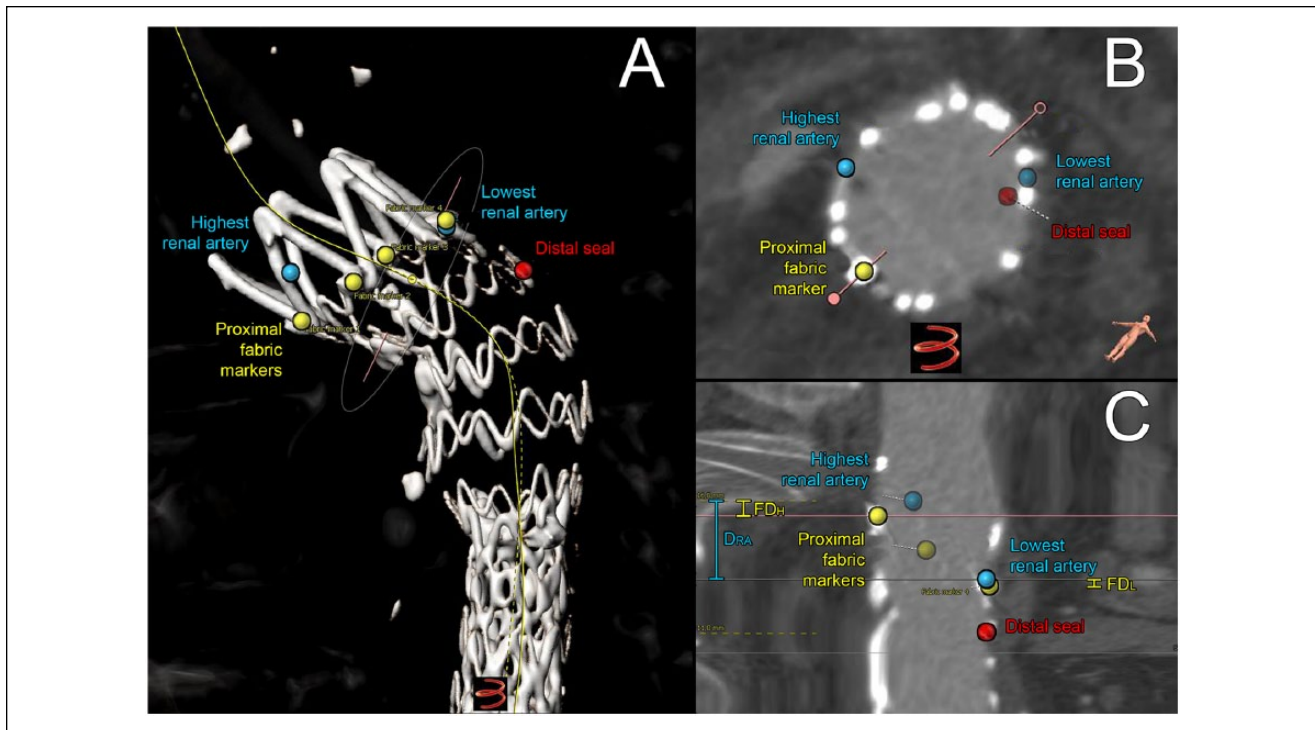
Postrepair computed tomography measurements on the 3mensio workstation displayed in (A) a 3-dimensional, (B) perpendicular to the centerline, and (C) stretched vessel views. Coordinates of the renal arteries, the 4 proximal fabric markers, and the distal end of the seal are displayed, as well as the centerline distances between the renal artery orifices (D_{RA}) and the fabric distances below the lower (FD_L) and higher (FD_H) renal arteries.
